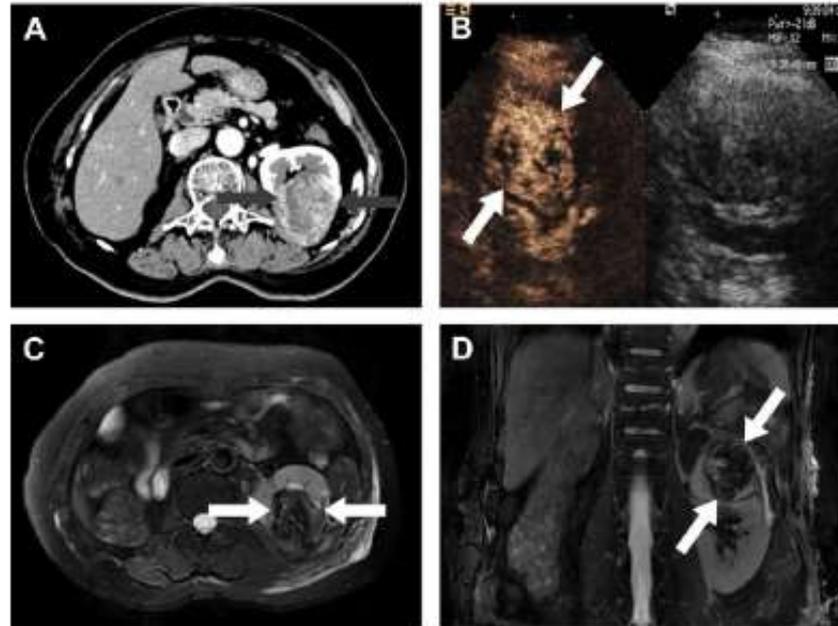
A 5.4×5.1 cm tumor lesion in a solitary kidney of a 66-year-old woman treated with microwave ablation. (A) Preablation enhanced-computed tomography image shows a heterogeneous hyperintense neoplasm (black arrow); (B) Contrast enhanced ultrasound shows the heterogeneous hyperenhancement neoplasm adjacent to the renal pelvis with the patient in a lateral position (white arrow); (C and D) On the post-microwave ablation magnetic resonance image, no
